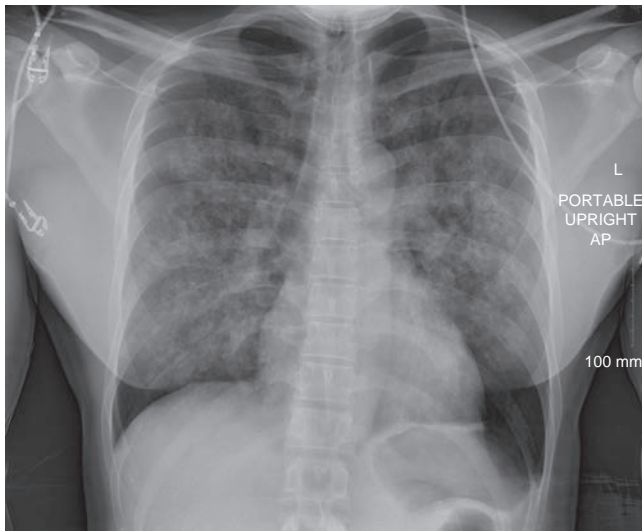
Chest radiograph in postobstruction pulmonary edema.
